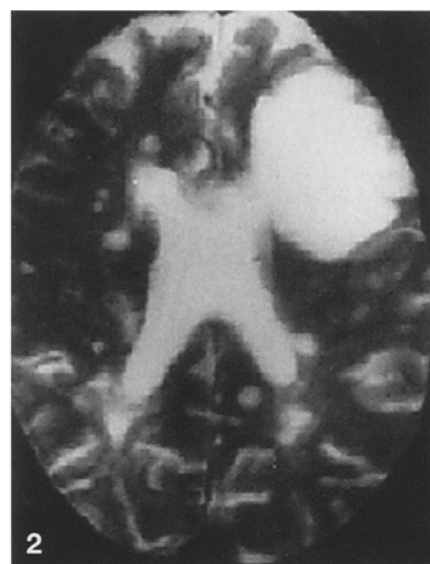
Case 5, a 56-year-old woman. T2-weighted image showing a large demyelinating lesion with a small ventricular interface. Other smaller deep white matter and periventricular lesions are present
